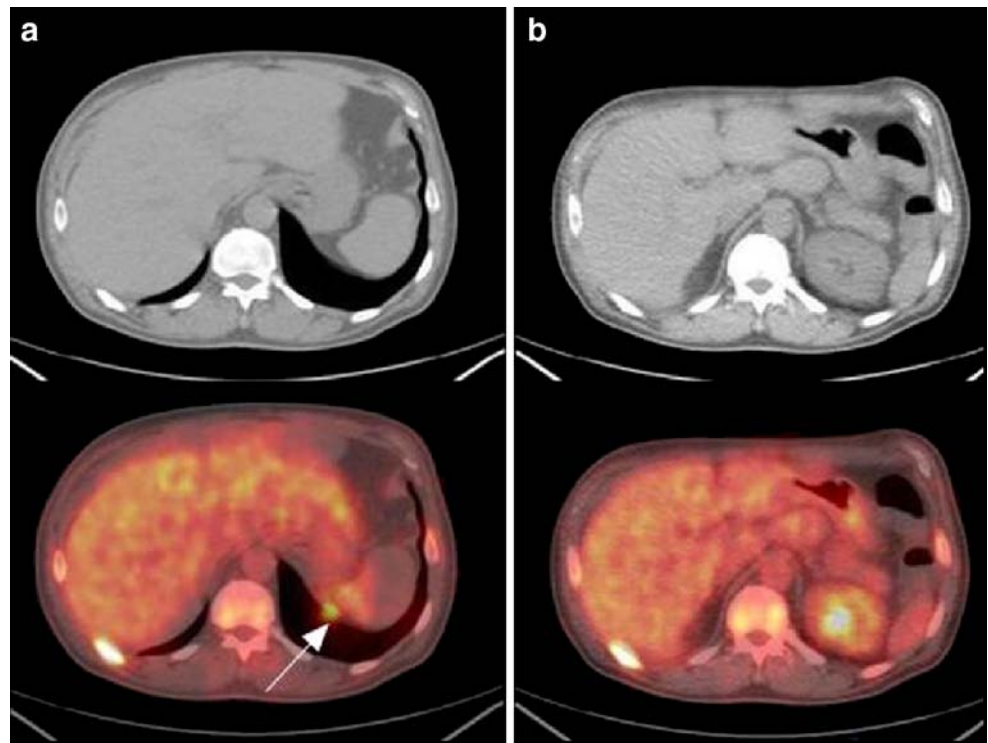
Problematic localization. Attenuation correction of the same PET data by HCT (a) and ACT (b) in a 48-year-old male patient with documented NSCLC at the right upper lung. The patient underwent PET/CT for primary staging. In the PET/HCT scan (a), left lower pleural seeding was highly suspected (T2N0M1, stage IV; AJCC 2002). However, no corresponding lesion was evident in the ACT scan (b). In the PET/ACT scan, a physiological accumulation of FDG radioactivity in the kidney (T2N0M0, stage Ib) – rather than pleural seeding – was observed
